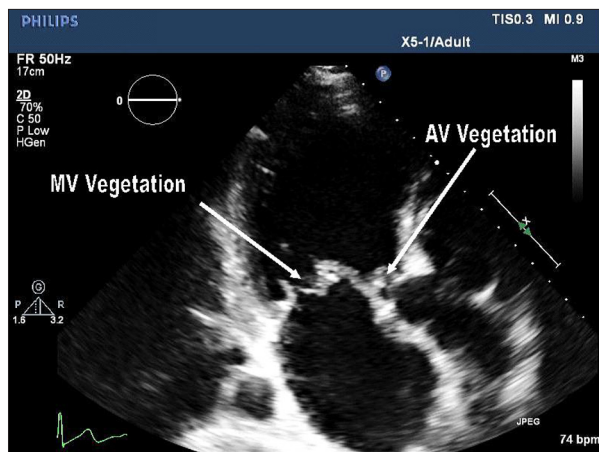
Apical 5 Chamber echocardiogram view showing mitral valve and aortic valve vegetations.
